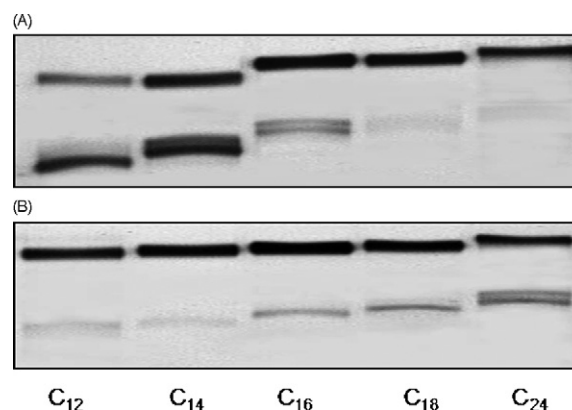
Metabolism of saturated fatty acids by Baculovirus expressed human CYP4A11 and CYP4F2 P450. Saturated fatty acid ω - and $\omega-1$ hydroxylation was measured in a reaction mixture of 20 μ g/ml dilauroylphosphatidylcholine, 100 pmol/ml CYP4A11 (A) or CYP4F2 (B), 1000 pmol/ml of cytochrome P450 reductase in 100 mM potassium phosphate buffer pH 7.4, 5 mM $MgCl_2$, 10 mM sodium isocitrate, 1 IU of isocitrate dehydrogenase and 1 mg/ml methyl- β -cyclodextrin containing 50,000 dpm of C^{14} labeled fatty acids (50 mCi/mmol) at final concentration of 200 μ M. Reactions were allowed to proceed for 30 min at 37 $^{\circ}C$ then terminated and fatty acid metabolites isolated and spotted on Silica linear K pre-adsorbent plates that were developed in hexane/ethyl acetate/isooctane/acetic acid/water (50/50/48.5/18.5/40) then exposed to X-ray film. The separation of ω - (lower band) and $\omega-1$ (upper band) hydroxylation metabolites of lauric ($C_{12:0}$), myristic ($C_{14:0}$), palmitic ($C_{16:0}$), stearic ($C_{18:0}$) and lignoceric ($C_{24:0}$) fatty acids are indicated.
